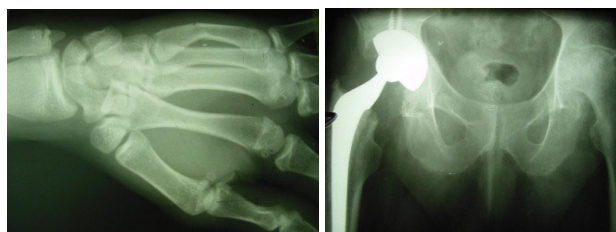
Sample X-ray images transmitted. Left image: right hand. Right image: pelvis. (Image size 210 Kbytes (tiff format), resolution 2000x1400).
